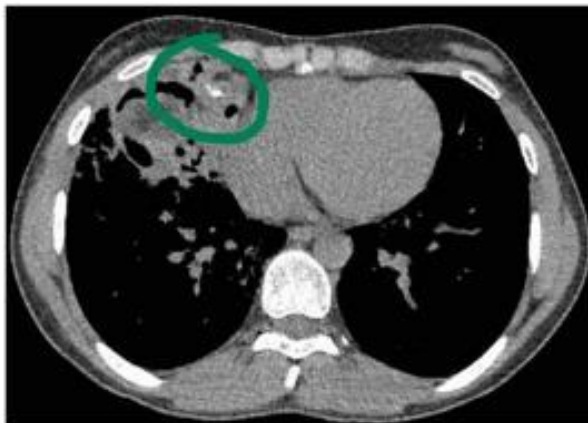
CT scan showing calcifications opacity and variant densities of tissues
